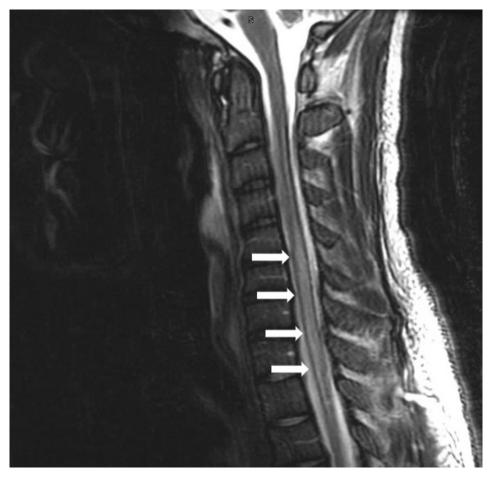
MRI cervical and thoracic spine Sagittal T2
